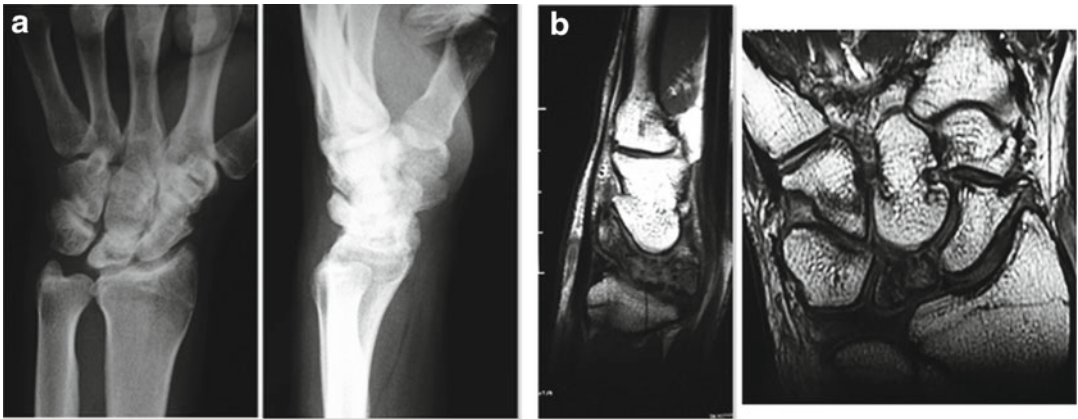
(a) A 22-year-old man with stage 3B disease on right wrist. Plain radiographs show lunate collapse with fixed flexion of scaphoid. (b) MRI showing low signal intensity on T1
